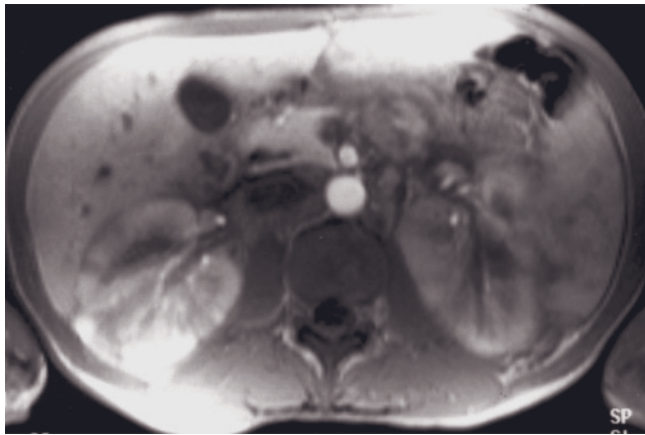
Acute pyelonephritis. T1-weighted precontrast (*a*) and 2-min postgadolinium (*b*) SGE images. The right kidney is swollen, and perinephric fluid (arrows, *b*) is present. No focal parenchymal abnormalities are identified. T1-weighted precontrast fat-suppressed SE image (*c*) in a second patient demonstrates striated, cone-shaped regions of high signal intensity in the medulla of the left kidney, consistent with proteinaceous material in acute pyelonephritis. Hydronephrosis of the right kidney is identified.
